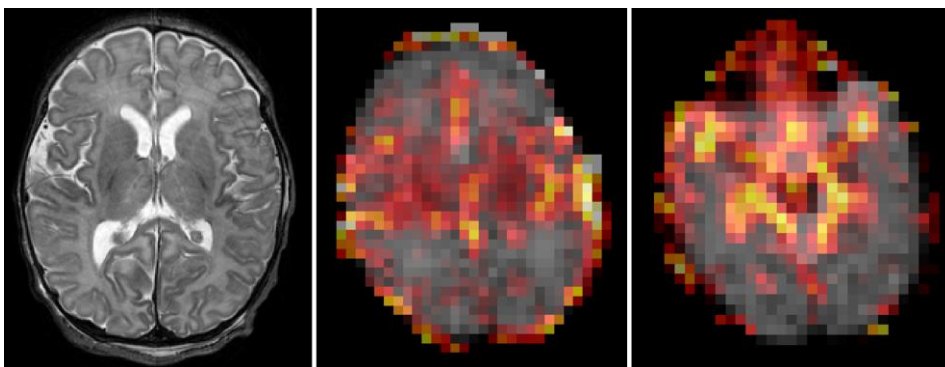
MRI and rCBF maps of infant ID22. T2 MRI: NICHD score 0. rCBF maps: lower perfusion.
